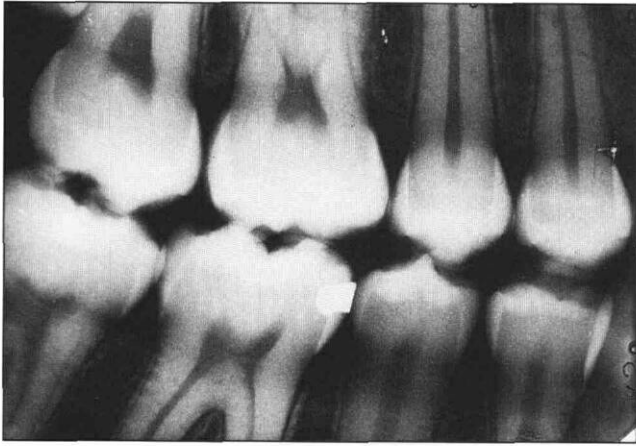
Bite-wing of the right side exposed at the 6 years follow-up examination, showing the right mandibular second premolar without any radiographic pathology.
